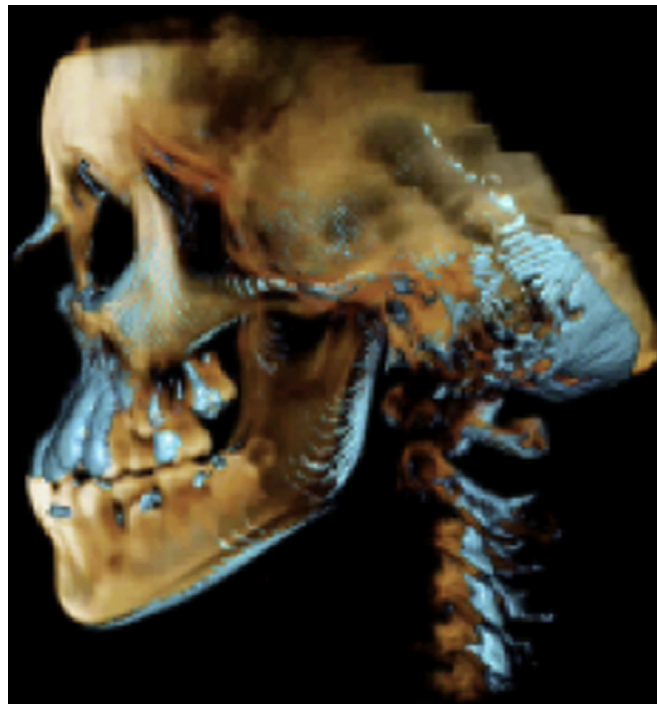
Superimposition of initial and final CBCT images using Anatomage software.
